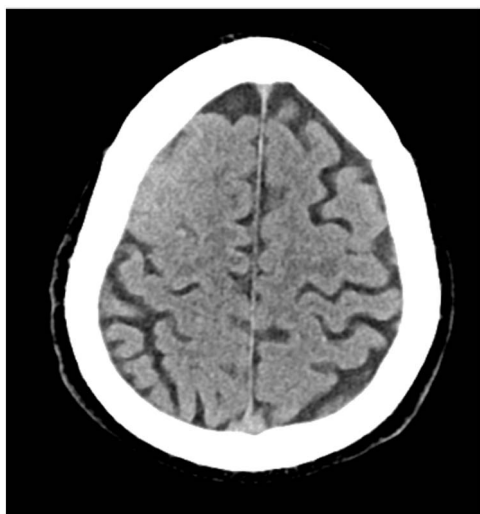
CT head demonstrates increased density in the sulci of the right frontal lobe which are isodense to gray matter suggesting leptomeningeal process.
